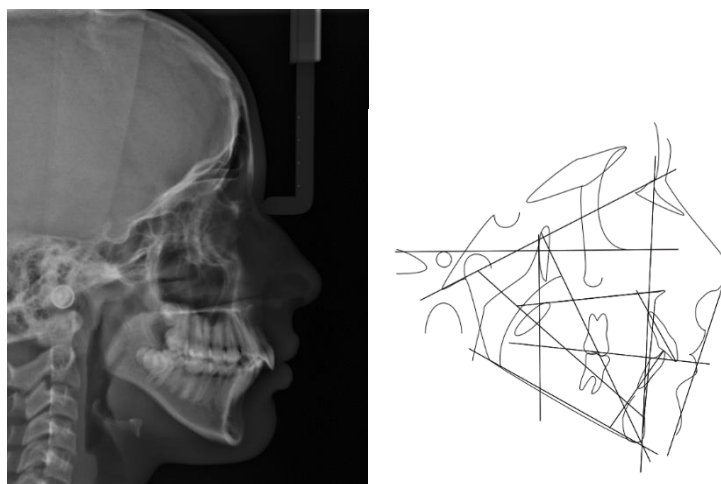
Lateral cephalometric radiograph (left) and corresponding Ricketts cephalometric analysis (right). Courtesy of K.F. Vasconcelos (Catholic University of Leuven).
